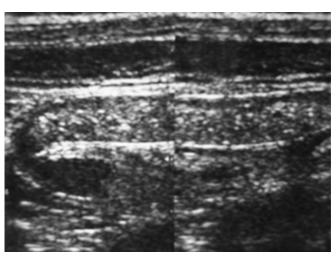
Ultrasonographic picture of an acutely inflamed appendix
